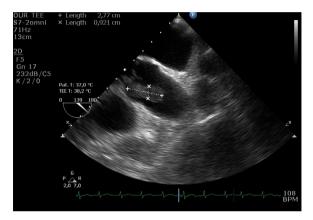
Transoesophageal finding of mass attached to the aortic valve.
